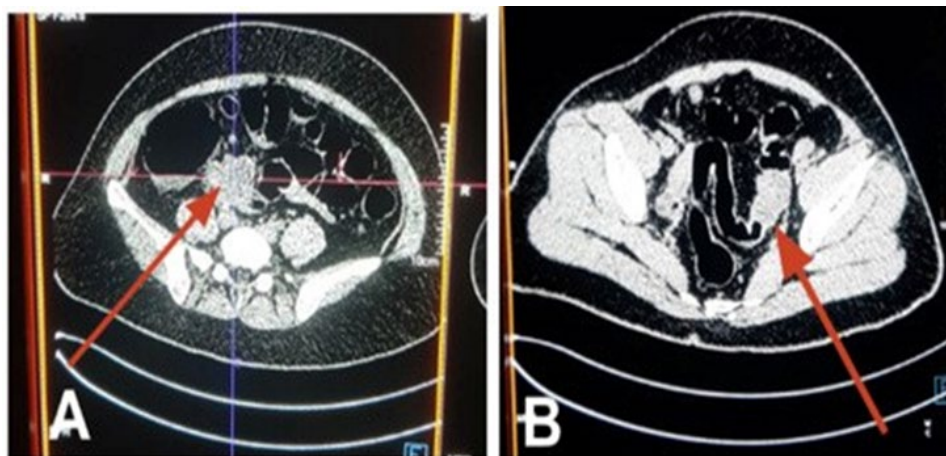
Abdominal CT scan (virtual colonoscopy). [A] Hypodense structure with cystic component and associated rim calcifications involving the ileocecal region measuring 6.6cm x 4.7cm x 4.3cm, remains intimately related to the right ureter. [B] Irregular circumferential wall thickening in the sigmoid colon with heterogeneously hypodense attenuation and associated with almost complete luminal obstruction
